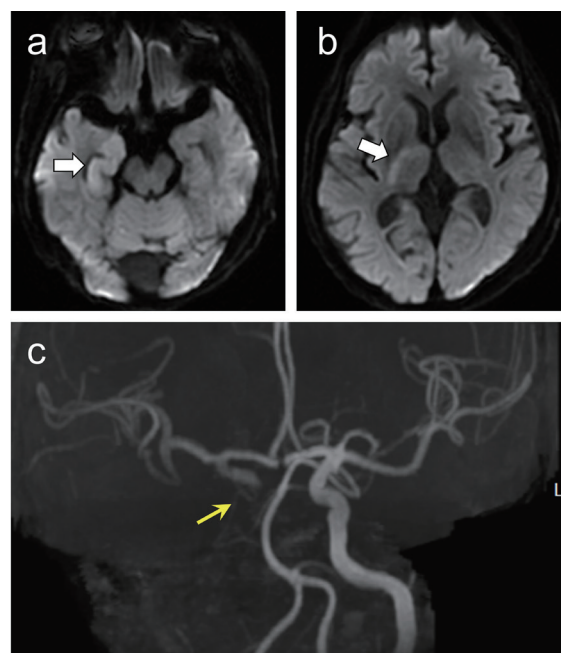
Multiple mild hyperintense areas at the right medial temporal lobe (a), frontal lobe, and posterior limb of internal capsule (b) on diffusion-weighted imaging, indicative of recent infarct (white arrows). (c) Time-of-flight magnetic resonance imaging (MRI) showed total occlusion at the right distal internal carotid artery (yellow arrow).
